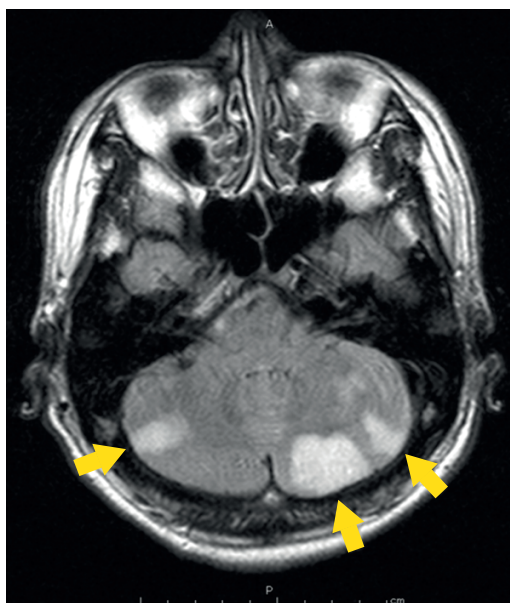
Brain magnetic resonance image. This image shows multiple cerebrovascular infarctions especially in the cerebellum.
